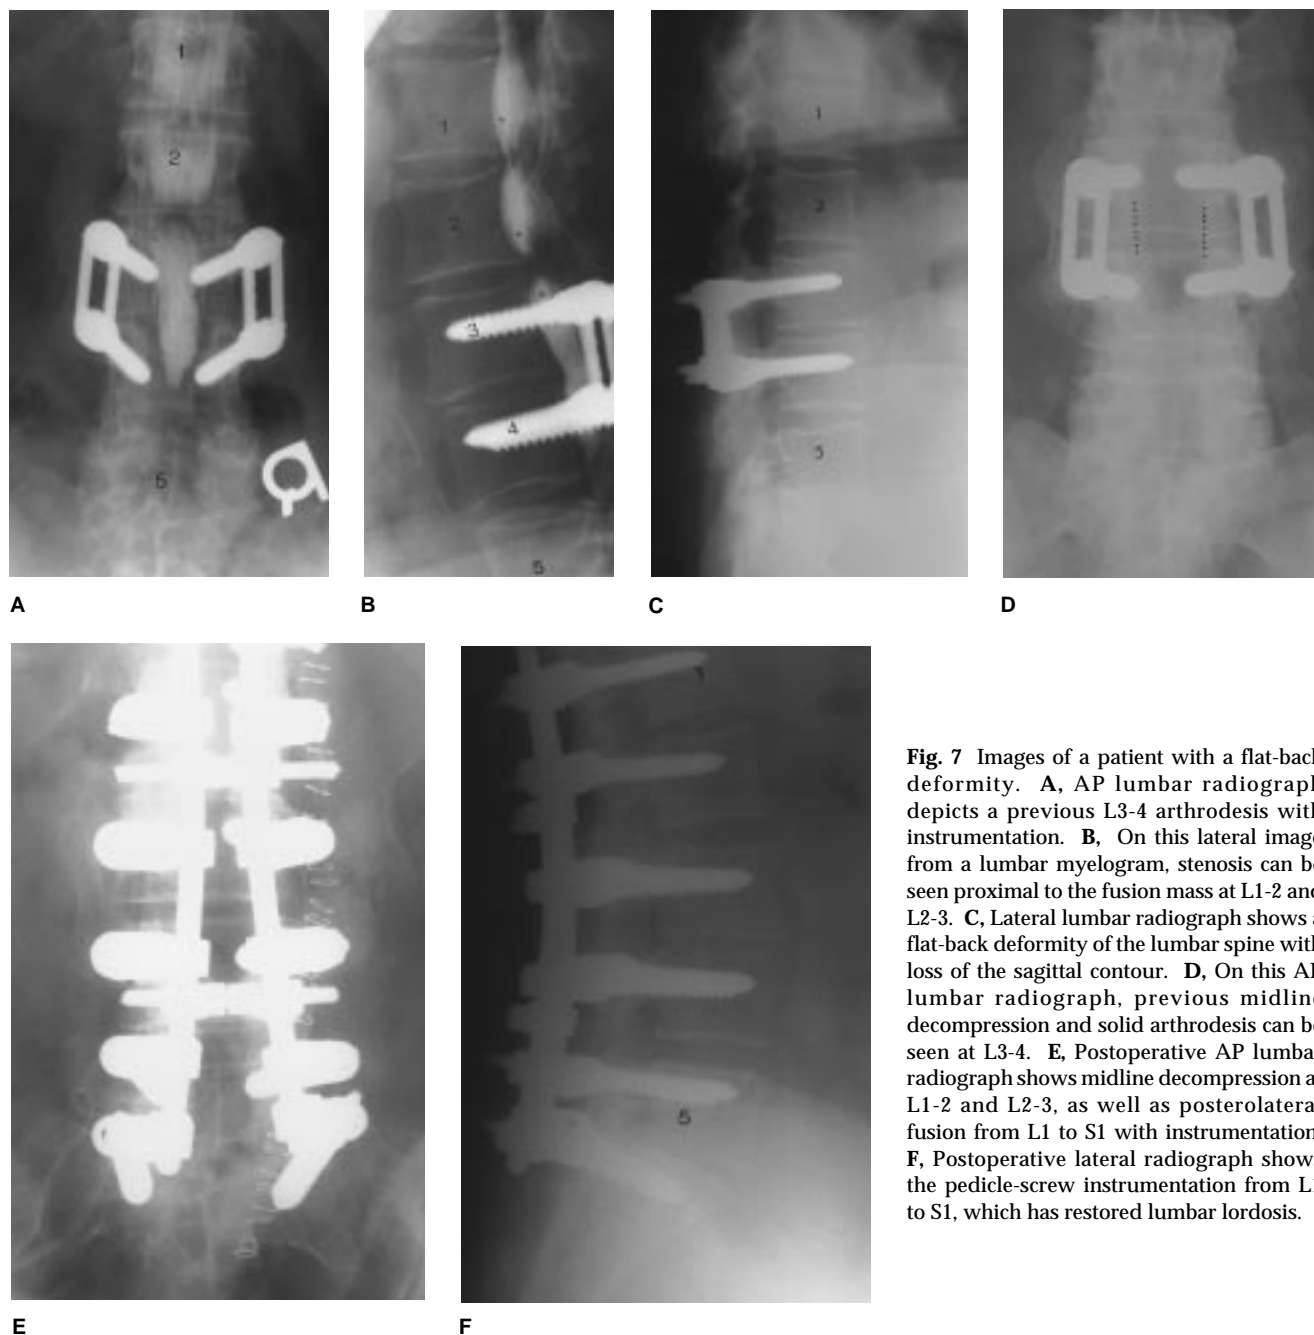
Images of a patient with a flat-back deformity. A, AP lumbar radiograph depicts a previous L3-4 arthrodesis with instrumentation. B, On this lateral image from a lumbar myelogram, stenosis can be seen proximal to the fusion mass at L1-2 and L2-3. C, Lateral lumbar radiograph shows a flat-back deformity of the lumbar spine with loss of the sagittal contour. D, On this AP lumbar radiograph, previous midline decompression and solid arthrodesis can be seen at L3-4. E, Postoperative AP lumbar radiograph shows midline decompression at L1-2 and L2-3, as well as posterolateral fusion from L1 to S1 with instrumentation. F, Postoperative lateral radiograph shows the pedicle-screw instrumentation from L1 to S1, which has restored lumbar lordosis.
